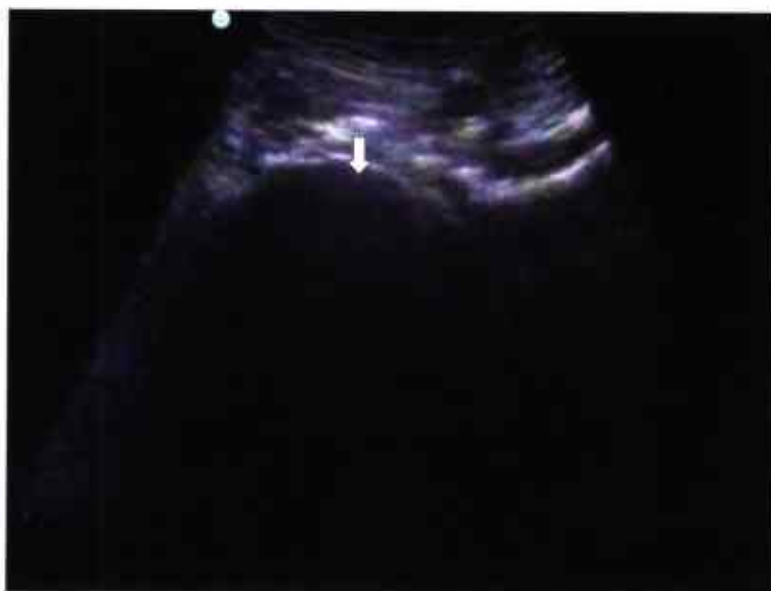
• Right hip ultrasound. Note the cortex of the head of the femur (indicated by arrow).
